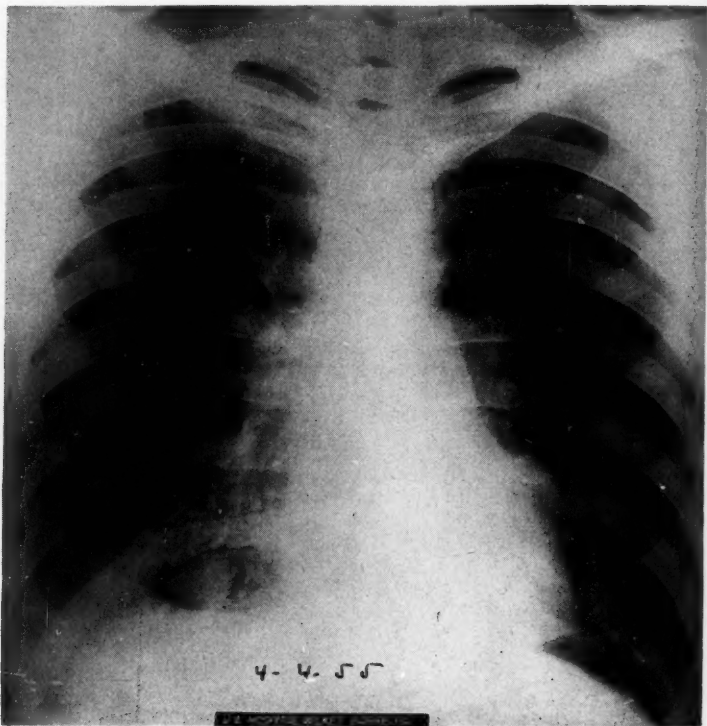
Chest x-ray on April 4, 1955, showing further clearing and residual fibrosis.
